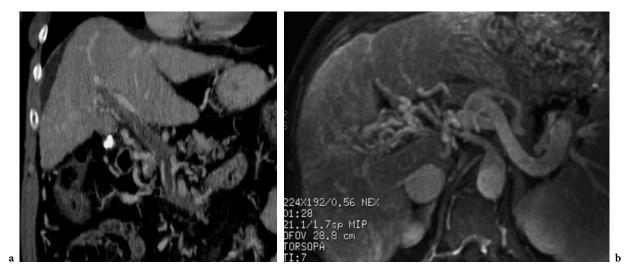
Portal vein pathologies. a MIP image reconstruction from a CT dataset shows complete thrombosis of the portal vein and of its right branch, and partial thrombosis of the superior mesenteric vein. b MIP image reconstruction from a MR dataset shows a portal cavernoma
